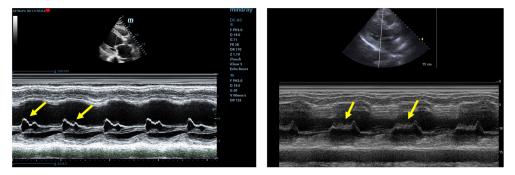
b.20. Fluttering of the anterior mitral valve (arrows) in a case with moderate (left) and severe (right) aortic regurgitation (parasternal long axis, M-mode)
